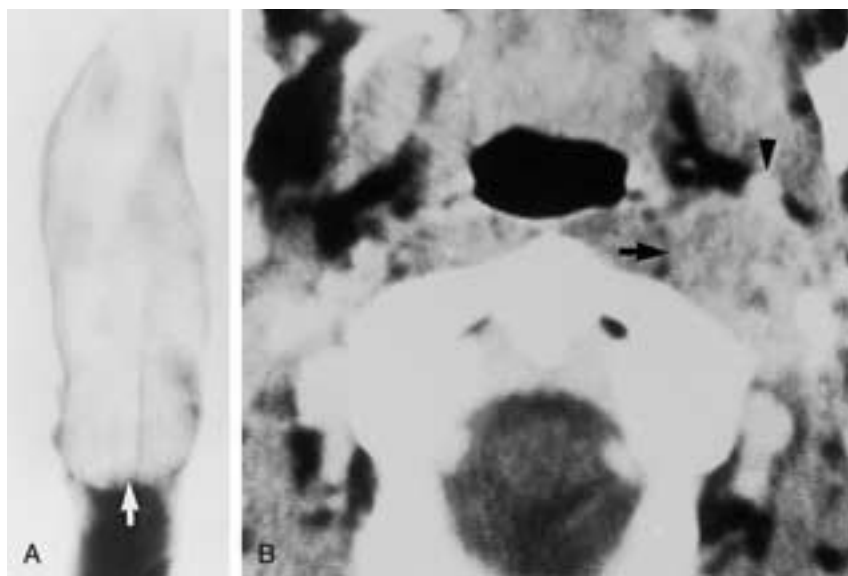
Intravenous extension of a glomus jugulare tumor. A, Retrograde jugular venogram. B, Postcontrast CT. An intravenous tumor (*arrow*) in the descending jugular vein is the common growth pattern of jugular paraganglioma. The ICA is displaced anteriorly (*arrowhead*).
